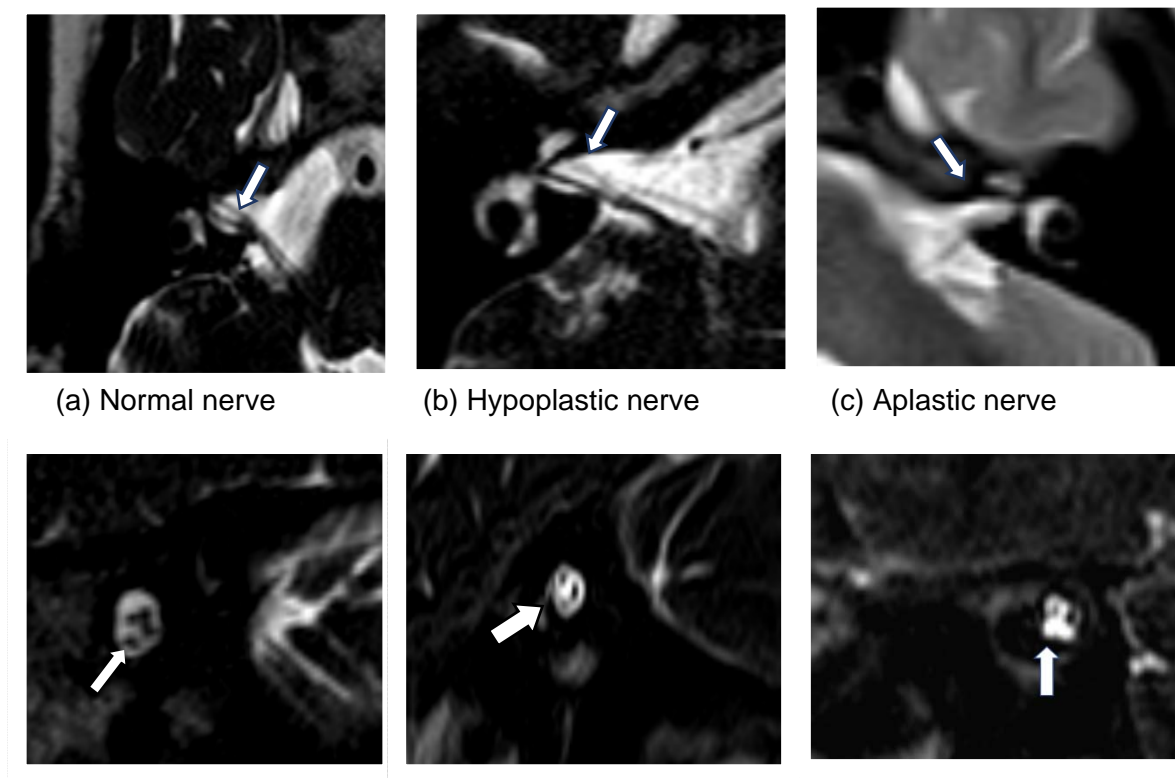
MRI axial and oblique sagittal cuts
